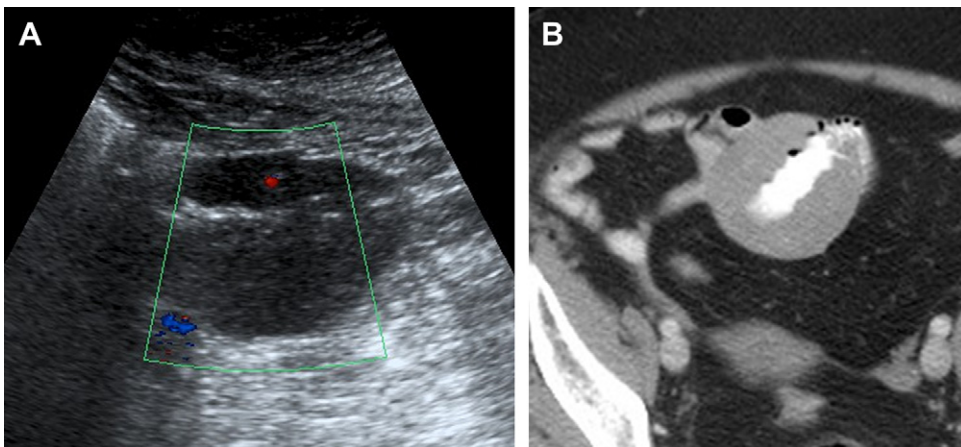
(A) Patient with right lower quadrant pain; short segment of hypoechoic eccentric bowel wall thickening with loss of stratification. (B) Same patient at CT. Lymphoma at surgery.
